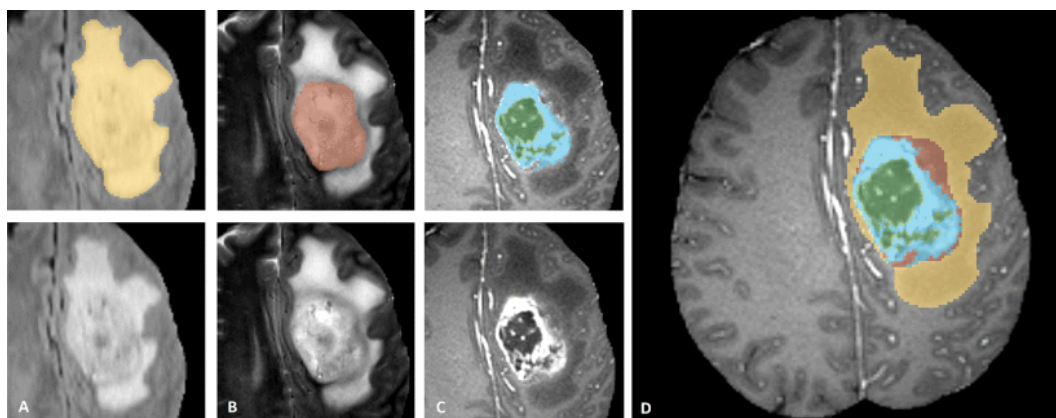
Clinical experts conducted manual annotation in the dataset. Progressing from left to right in the image patches: the entire tumor appears in FLAIR-MRI (A), the tumor core is evident in T2-MRI (B), and the enhancing tumor lesions can be observed in T1-ce (depicted in blue) encircling the necrotic components of the core (depicted in green) (C). These segmented tumor lesions are combined, shown in (D): edema (depicted in yellow), non-enhancing (solid tissue) (depicted in red), necrotic (fluid tissue) (depicted in green), and enhancing core (depicted in blue). [Menze et al. (2014)].
